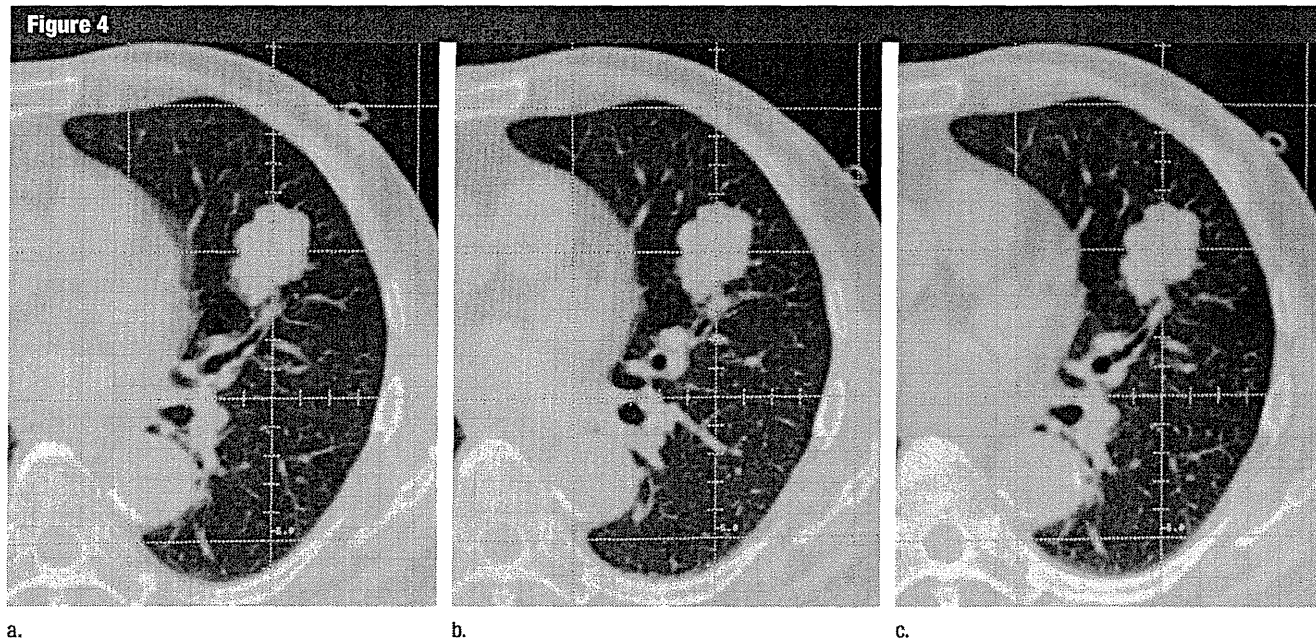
CT images obtained during voluntary breath holding with the device. Before every session of radiation therapy, a set of three CT scans is performed to obtain randomly timed images of 2 mm thickness in the vicinity of the tumor. (a–c) Images obtained with the first, second, and third scan, respectively. The scanning interval was approximately 5 minutes. Maximum differences in tumor position in craniocaudal, anteroposterior, and right-left directions on three CT studies were 1, 0.7, and 0.5 mm, respectively.
